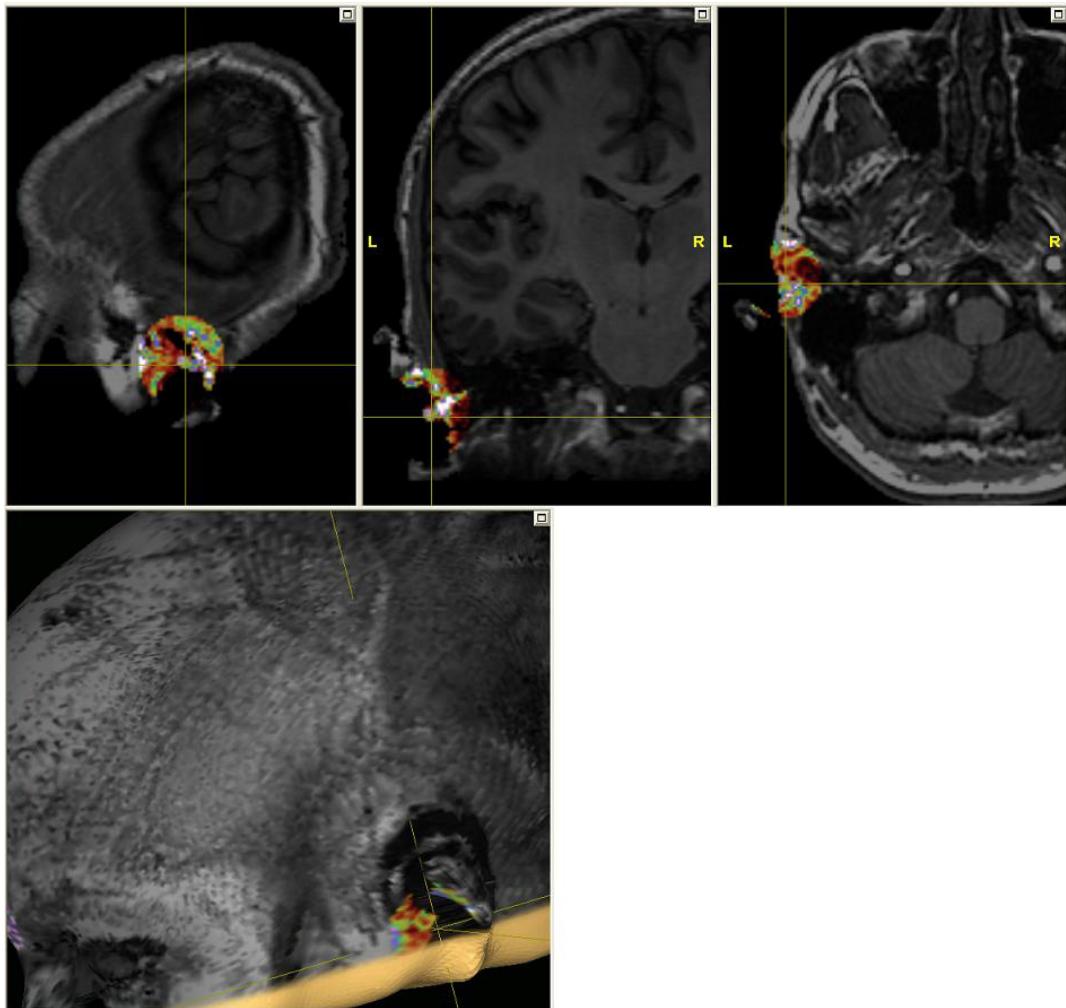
Rainbow colormap: Location of the left ear landmark in the MR images and 3D head
